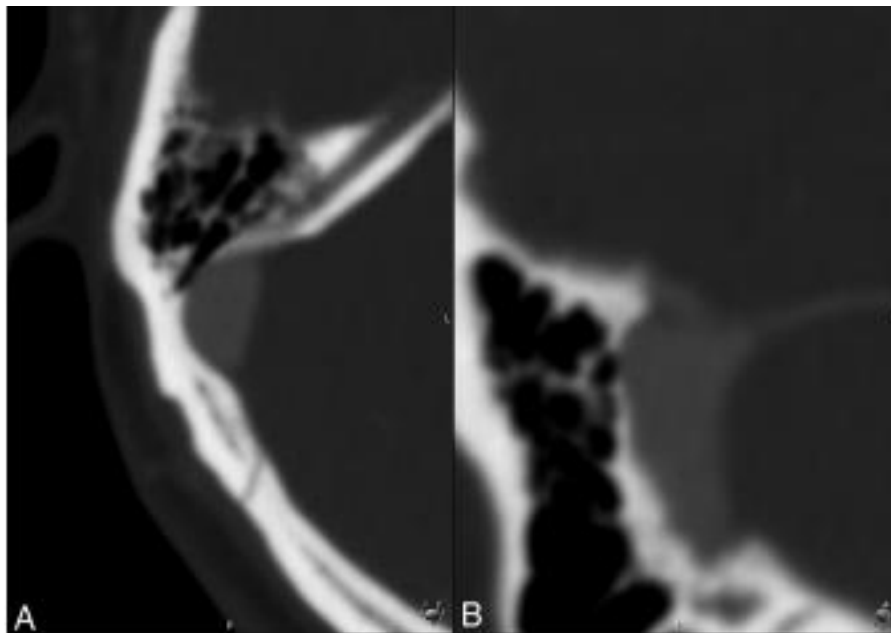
CT axial cut of right side temporal bone. Dehiscence of the sigmoid sinus wall: “air-on-sinus“ sign in the axial (A) and sagittal planes (B)¹⁸
